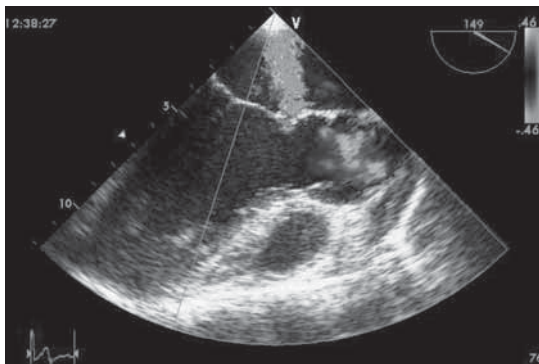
Transesophageal echocardiographic view of the perforation
